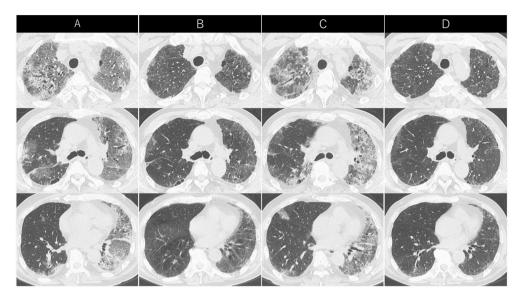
Chest high-resolution computed tomography (HRCT) images of the upper and lower lobes. (A) On the day of admission, extensive ground-glass opacities and consolidation were seen predominantly in the left lung, and traction bronchiectasis and volume reduction were also present. (B) On the 26th hospital day, antiviral therapy and corticosteroid treatment including two rounds of steroid pulse therapy resulted in a marked reduction of ground-glass opacities and consolidation although reticular shadows indicative of fibrotic changes were still present. (C) On the 39th hospital day, ground-glass opacities and consolidation reappeared in the bilateral lungs superimposed on reticular shadows indicating residual fibrotic change after COVID-19 pneumonia along with hemoptysis, purpura, and thrombocytopenia. A diagnosis of diffuse alveolar hemorrhage was made by bronchoalveolar lavage after the patient was intubated. (D) On the 51st hospital day, HRCT findings improved markedly with the increase in corticosteroid dosage.
